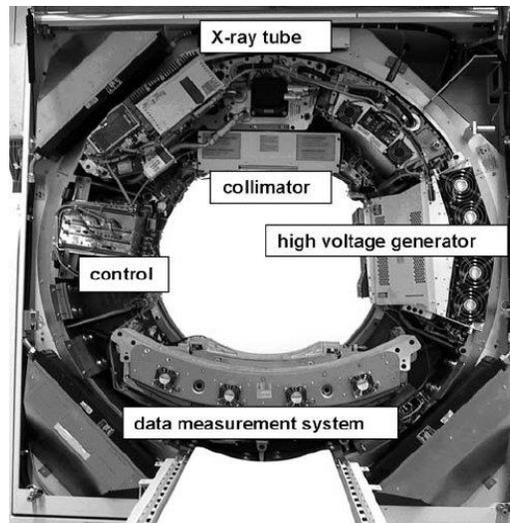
Basic system components of a modern third-generation CT system.
